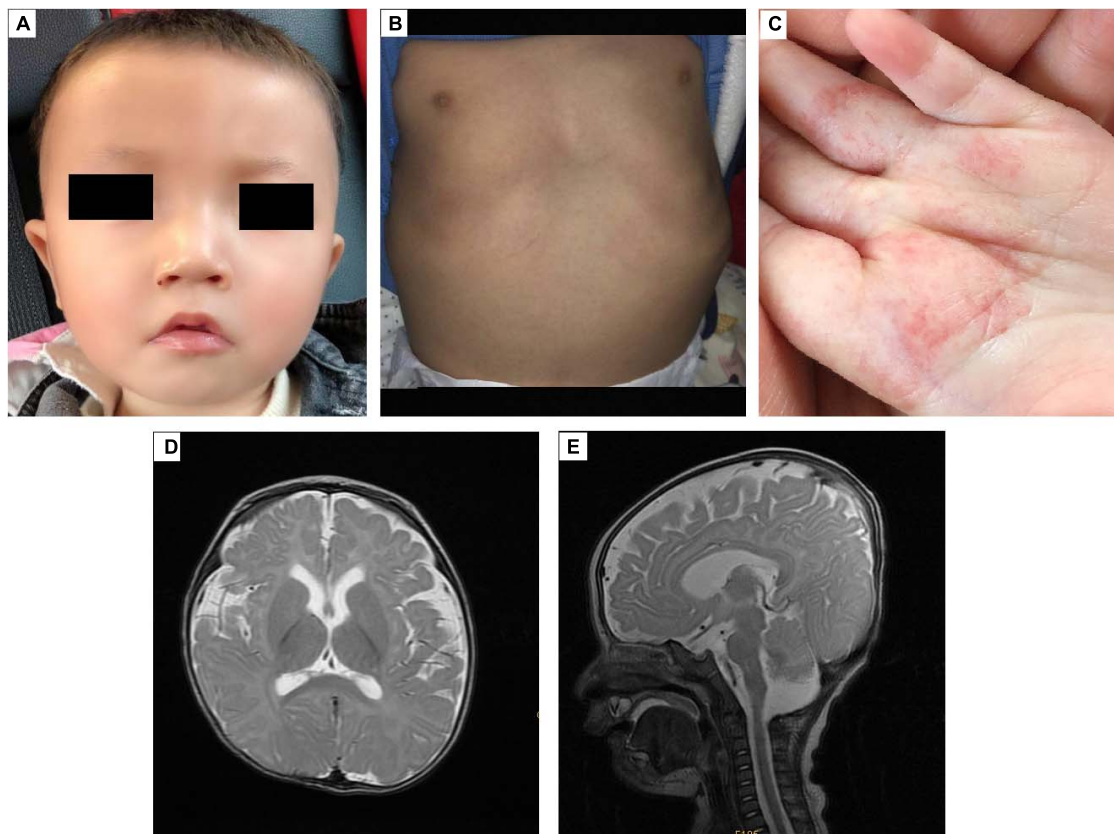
The appearance and MRI results of the patients. (A) The patient has an unclosed fontanelle, slight orbital hypertelorism, high nasal bridge, broad nasal tip, deep philtrum, and downturned mouth. (B) The patient has pectus excavatum. (C) The hemangiomas are in the palm of the left hand. (D,E) Brain MRI shows insignificant T2 hyperintensity at the bilateral anterior limbs of the internal capsule, enlargement of the bilateral lateral ventricles and lateral apertures.
